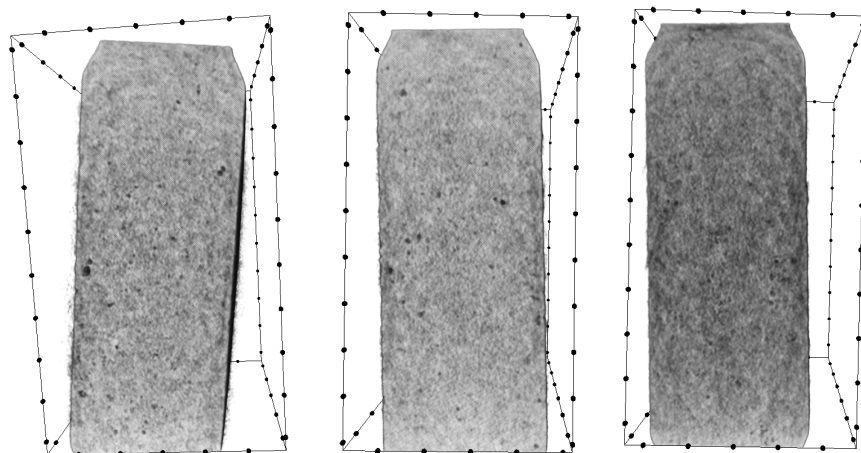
X-ray μ -CT images of DF THL VitE tablets prepared with M21D (left), ISM (middle) and 50%MTL (right) as filler.
